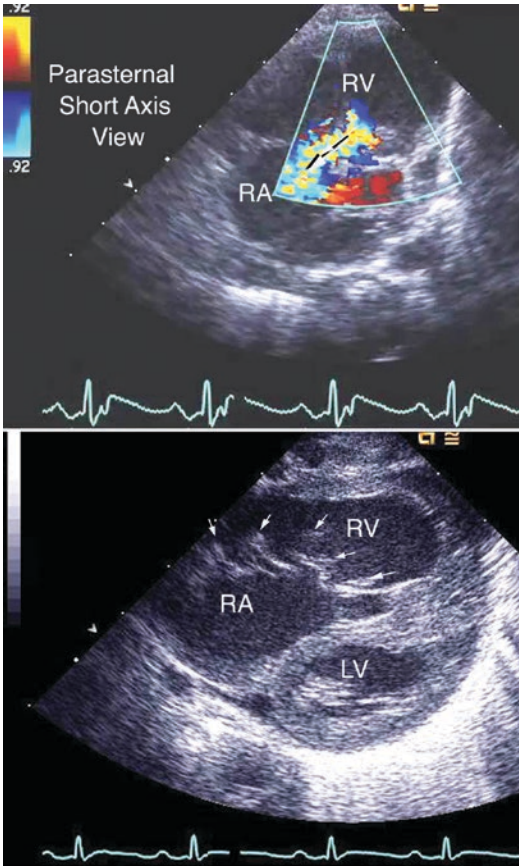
This parasternal short axis view taken at the level of the ventricles shows the Doppler color flow image above and the gray scale image below. The right atrium (RA) right and left ventricles (RV and LV) are shown. The enlargement of the right ventricle pushes the ventricular septum backward, diminishing the size of the left ventricle. In the *top frame*, the direction of the tricuspid regurgitant jet is from the displaced apposition of the valve as shown by a highlighted arrow. In the *bottom frame*, small arrows show the attachments of the chordae tendinae to the tricuspid valve
